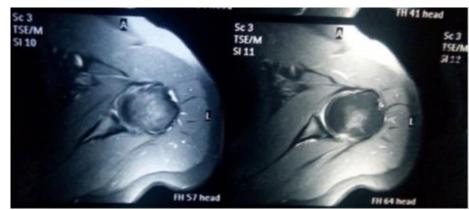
Preoperative MRI shows Bankart lesion and small hillsach's lesion with osseous edema CT scanning is currently the method of choice for studying glenoid bone defects for recurrent dislocations. Strongly positive apprehension test at minimum degrees of abduction, bone defects shown on plain radiographs, and the need for surgical stabilization are the main indications for performing a CT study (figure 2) ^(7, 21, 23, and 24).
